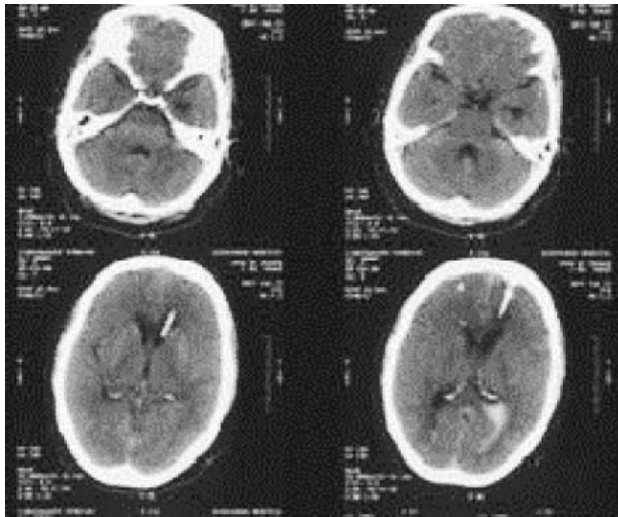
CT image of brain scans of the same patient taken 11 days after rapid pore cranial drilling with external drainage. The catheter of the right lateral ventricle had been dislodged. The intraventricular hemorrhage had disappeared.
